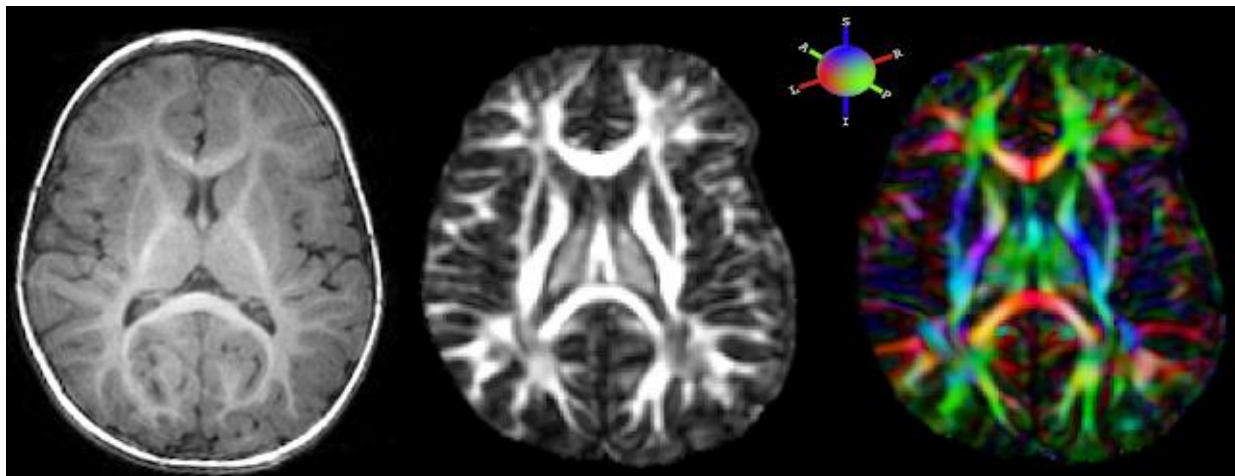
Diffusion tensor image (DTI) displayed as a raw T1-weighted MR image (left), along with corresponding fractional anisotropy (FA) maps in greyscale (middle) and color (right) (Tromp 2009). Fractional anisotropy is a method which quantifies the relative length of each diffusion tensor in comparison to its width, or analogously quantifies the fraction of the tensor that is non-isotropic (Tromp 2009). This provides a measure of the direction of diffusivity of water molecules in the brain, which move preferentially along white matter tracts but more randomly within gray matter (Tromp 2009).
